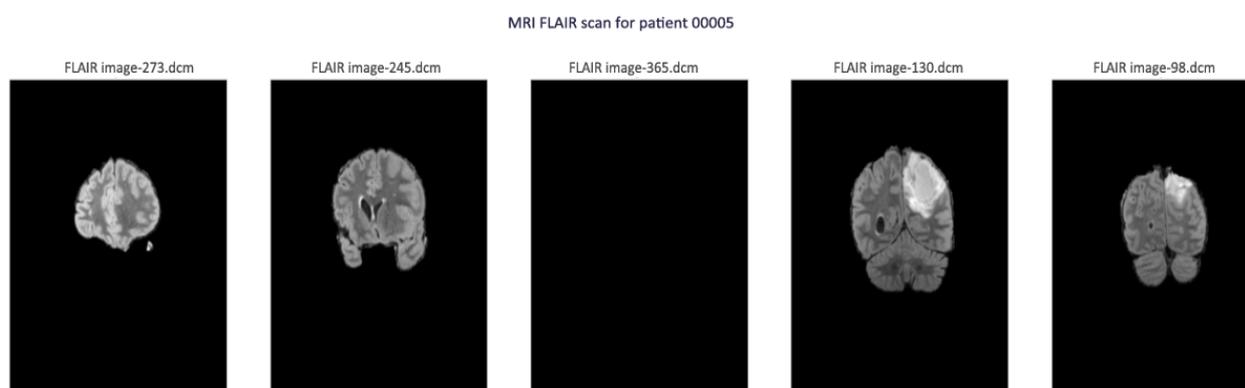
MRI FLAIR scan.
